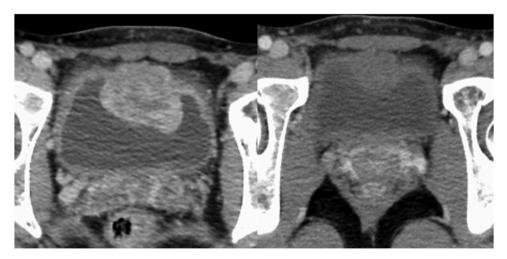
Left, Before treatment, CT showed a mass measuring 49 mm in diameter. Right, After treatment, the tumor size reduced to 25 mm.
